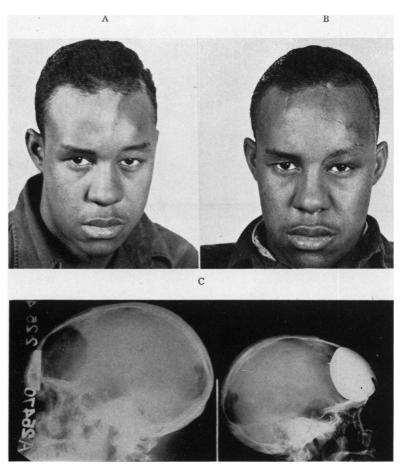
Case 3 (A) Skull defect following resection of osteomyelitic bone. (B) Same patient following tantalum cranioplasty. FIG. 7.—Case 3 (C) Roentgenograms of skull defect and tantalum repair.
